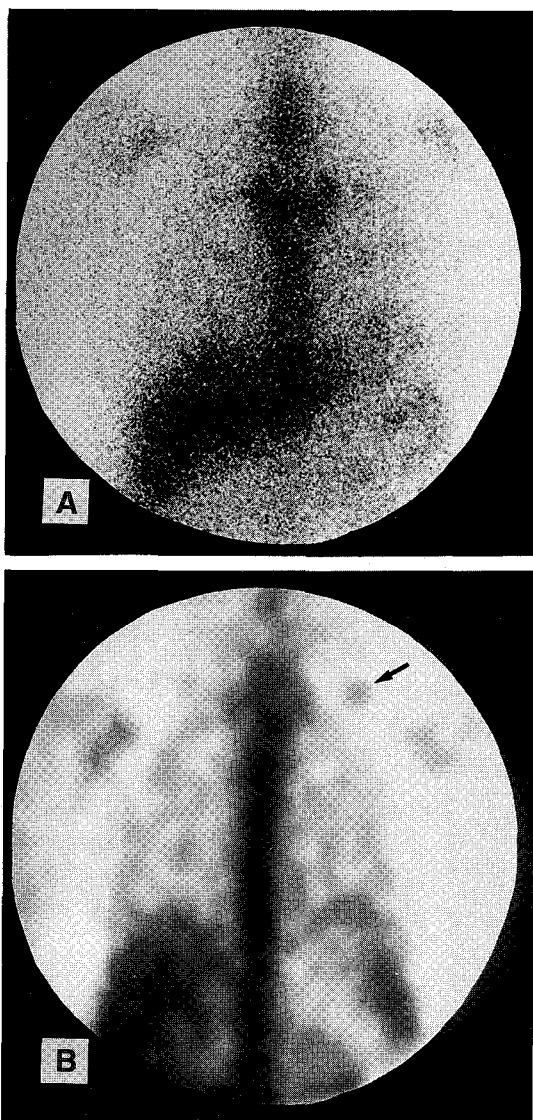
A 21-year-old patient with Non-Hodgkin's lymphoma. (A) Ga-67 planar image reveals no abnormal uptake in the neck. (B) Ga-67 SPECT image (coronal section) shows a focal uptake in left lower cervical lymph node which is proved as lymphoma by biopsy (diameter about 2cm).
